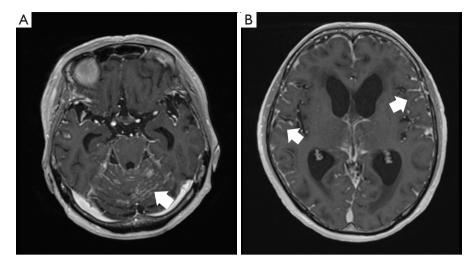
This neurological image shows signs of meningitis, with inflammatory signs around the cerebellum and brain stem appearing as linear enhancements in the image, and similar linear enhancements as inflammatory signs are also seen in the sulci of the cerebellum (arrows). (A) T1WI of postcontrast MRI demonstrates abnormal linear enhancement around the brainstem and along the cerebellar folia. (B) T1WI of the postcontrast MRI demonstrates abnormal linear enhancement along the cerebral sulci (arrows) of the longitudinal fissure. T1WI, T1-weighted image; MRI, magnetic resonance imaging.
